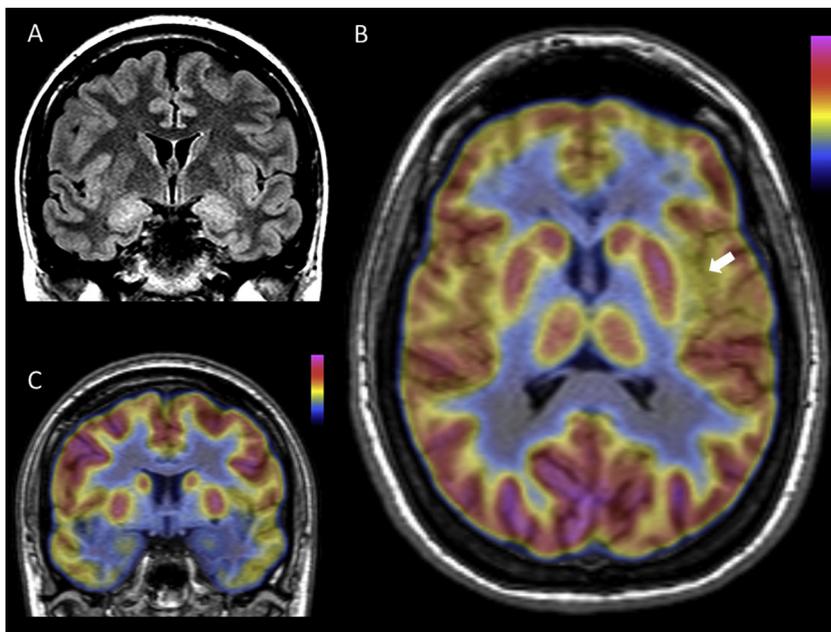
Neuroimaging showed bilateral temporal and left insula involvement. Panel A. Brain magnetic resonance imaging fluid-attenuated inversion recovery coronal section: hyperintensity in both mesial temporal lobes and left insula. Panel B. Brain FDG-PET axial section: hypometabolism in the left insula (white arrow). Panel C. Brain FDG-PET coronal section: hypometabolism in the mesial temporal regions.
